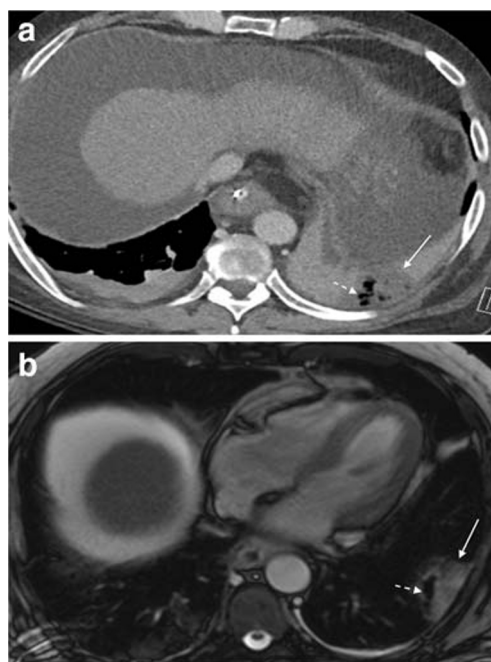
Necrotizing pneumonia in a man presenting with sepsis. a Contrast-enhanced axial CT image shows left lower lobe consolidation with focal area of hypo-enhancement (white arrow) containing interspersed gas (dashed white arrow). b MR axial TRUFISP after a few days showing mild improvement in left lower lobe consolidation (white arrow) with persistent gas seen as hypointense foci (dashed white arrow)
